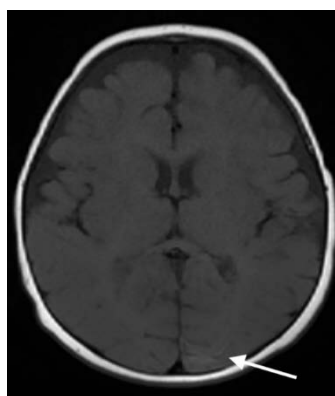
Hyperintensity (arrow) in the left occipital gyral pattern on precontrast T1-weighted MR imaging is consistent with hemorrhage.
